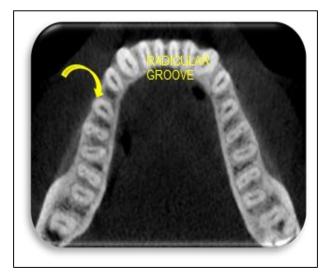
Axial view of CBCT: at middle one third.
